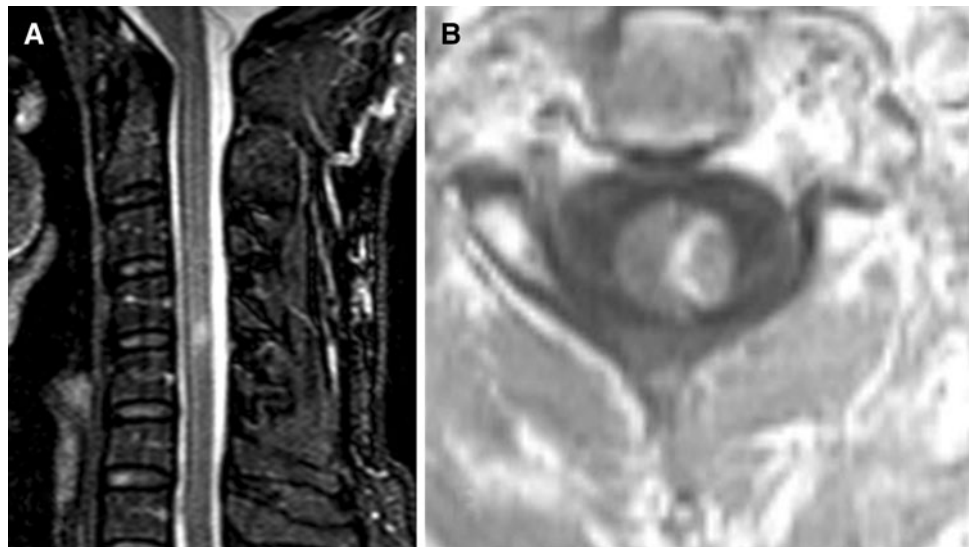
MRI of NMO-associated myelitis. Sagittal T2-weighted MRI of the cervical spinal cord demonstrates a longitudinally extensive high signal intensity extending from C2 to T1 (a). Axial T2-weight
